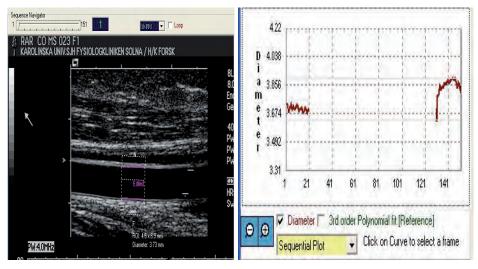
The ultrasound images and automatical measurements of the diameters of the brachial artery for the calculation of FMD.
